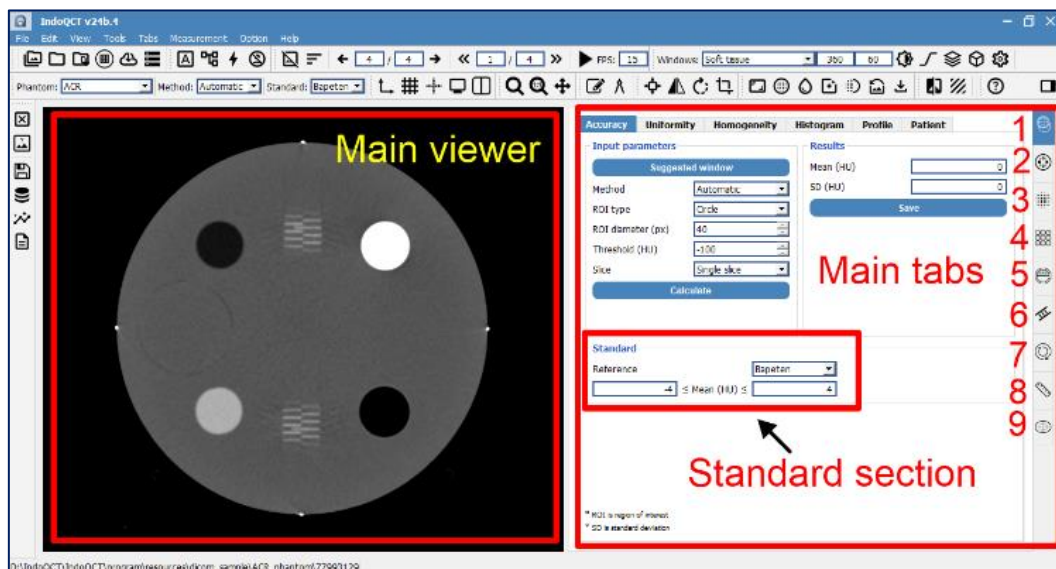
The graphical user interface of IndoQCT. It consists of a main viewer, main tabs, and standard sections. A total of 9 main tabs for the measurement of different image quality parameters is provided: (1) CT number of water, (2) CT number of multiple objects, (3) Noise, (4) Spatial resolution, (5) Low contrast detectability, (6) Slice thickness, (7) Laser alignment, (8) Distance accuracy, and (9) Gantry tilt
